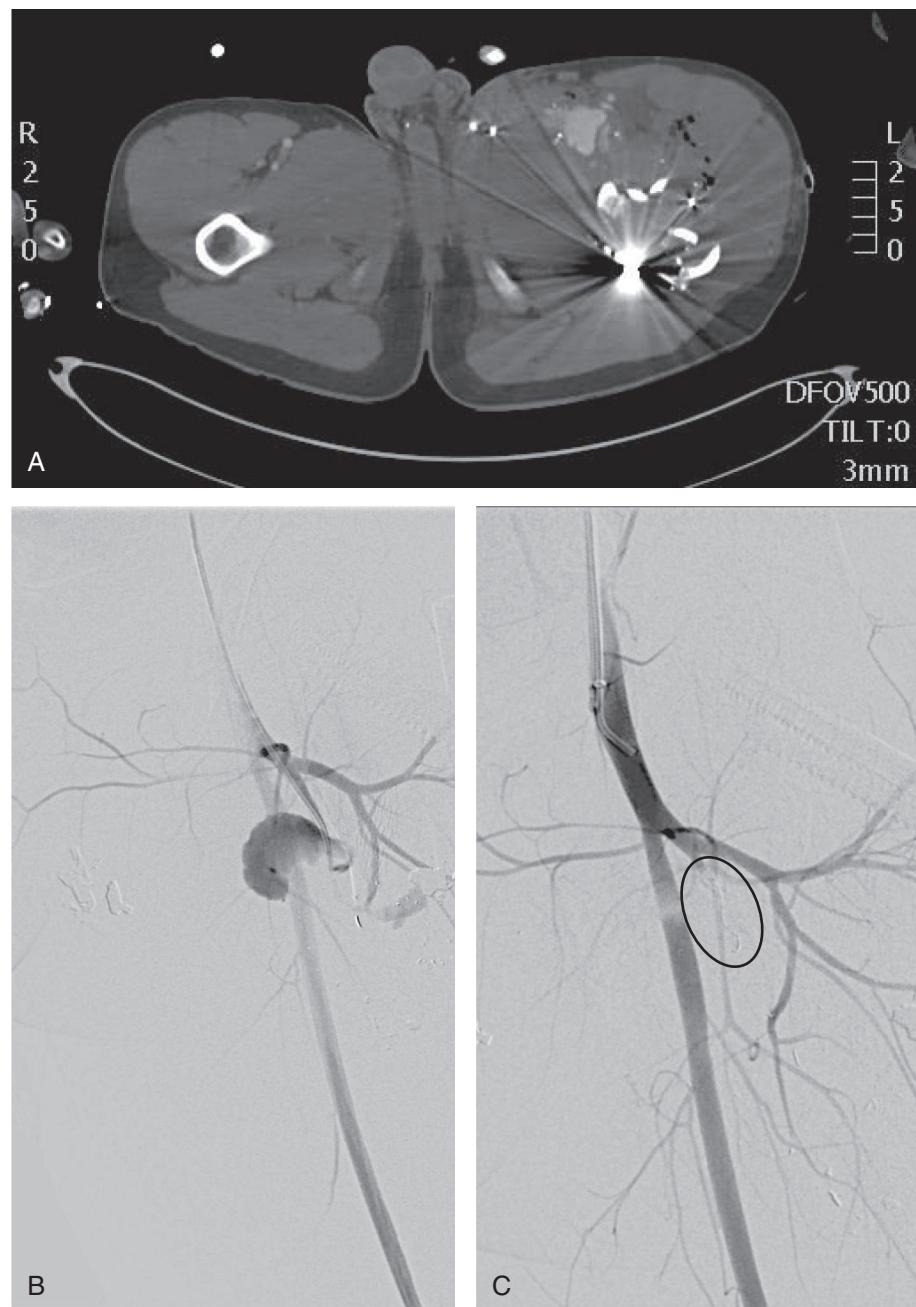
(A) Computed tomography angiography image demonstrating pseudoaneurysm of a profunda femoris artery (PFA) branch with thigh hematoma. (B) Femoral angiography revealing the PFA branch disruption. (C) Successful coil embolization of the disrupted PFA branch (*oval*).
